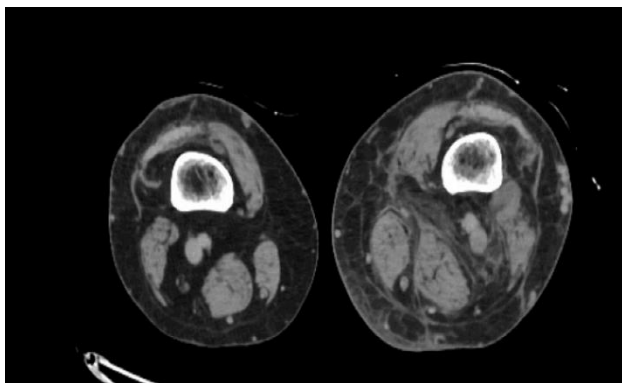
CTA abdominal aorta and bilateral iliofemoral runoff showing questionable thrombus within the left distal superficial femoral vein/popliteal vein.
